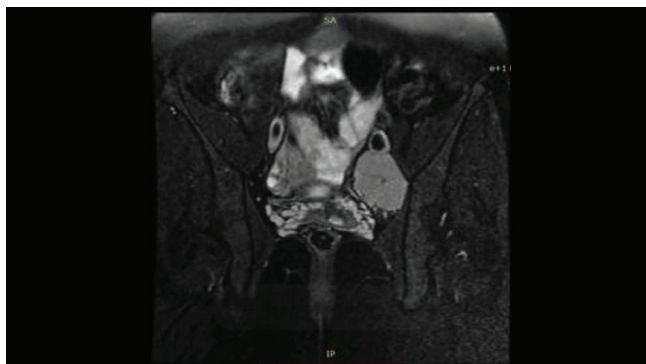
MRI showing lesion in left obturator fossa
